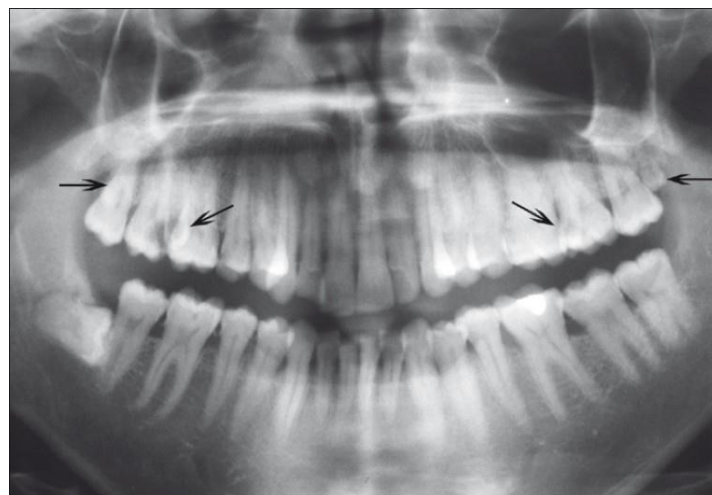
Radiograph showing maxillary bilateral paramolars and distomolars
